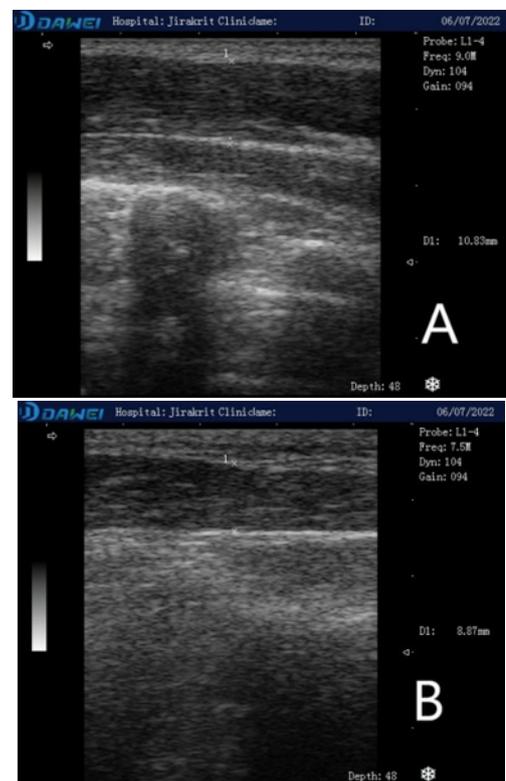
Ultrasonography between before (A) and after therapy (B). The thickness of the upper trapezius muscle was 10.83 mm. before and after Tok Sen therapy (8.87 mm) by ultrasound imaging.
